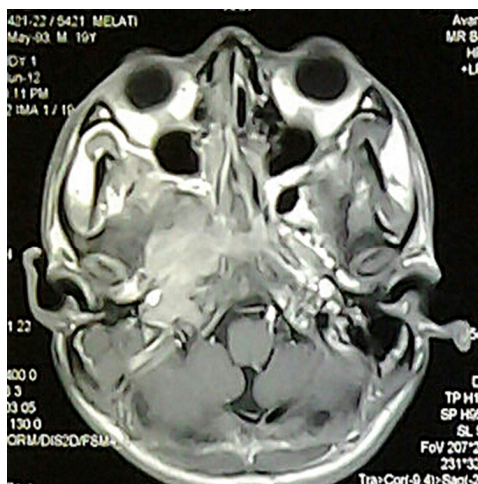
Magnetic resonance imaging showing an enhancing extradural lesion in the right temporal region. The lesion is seen to encase the petrous portion of right internal carotid artery without involvement of the cavernous sinus and cavernous portion of right ICA are preserved.
